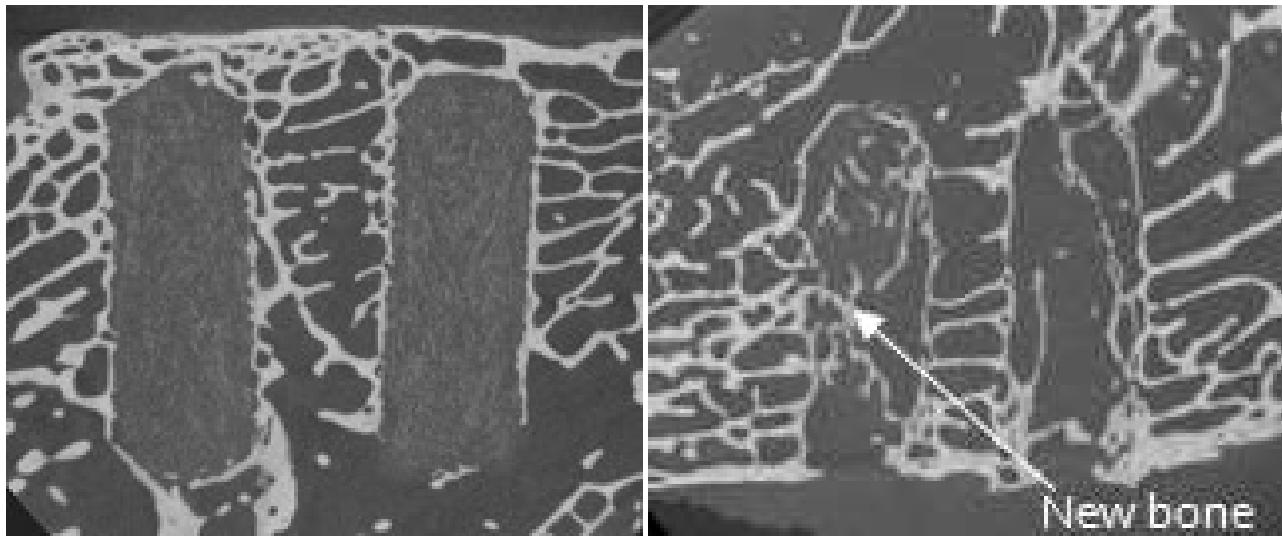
μ CT images of the implant at 52 (left) and 104 weeks (right). White areas represent bone tissue.
